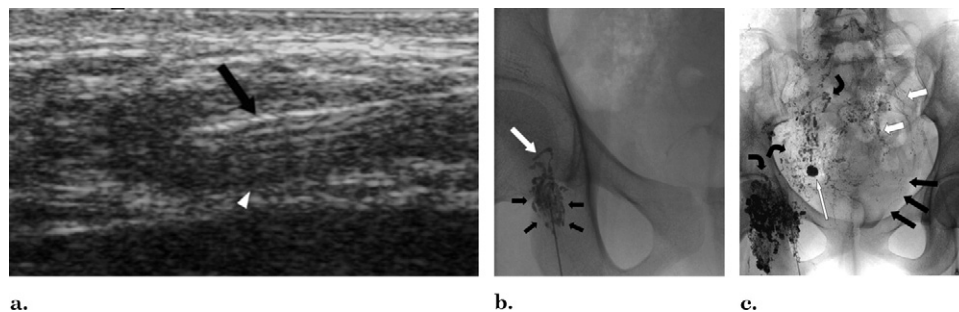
Patient 2. (a) US image shows the proper position of the needle (arrow) within the lymph node (arrowhead). (b) A spot radiograph of the right groin demonstrates the initial phase of intranodal injection of ethiodized oil, with opacification of the lymph node (black arrows) and adjacent efferent femoral lymphatic channels (white arrow). (c) There is extensive ectasia and incompetence of the femoral, iliac, and retroperitoneal lymphatics (bent arrows), with focal areas of leak (long white arrow). Note reflux from incompetent right external and common iliac lymphatics into ipsilateral and contralateral iliac chains (thick white arrows) as well as into the pelvic organs. The faintly opacified uterus is marked by black arrows overlapping with contrast in the urinary bladder.
